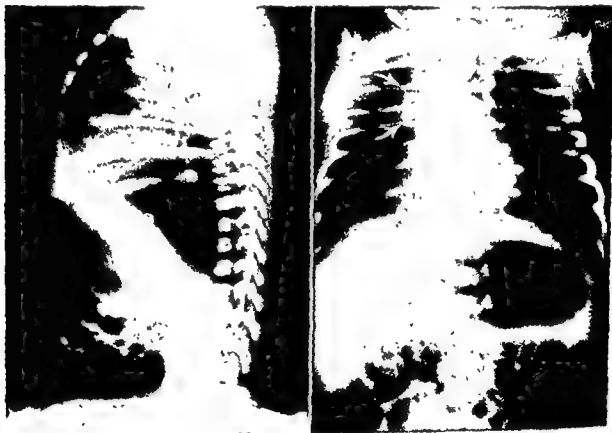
Esophageal atresia with tracheo-esophageal fistula. X-ray examination with radiopaque medium filling the proximal blind pouch of esophagus. Gas in the abdomen indicates that there is a communicating fistula between the trachea and lower esophagus. There is evidence of atelectasis in the right upper lobe (arrows).
